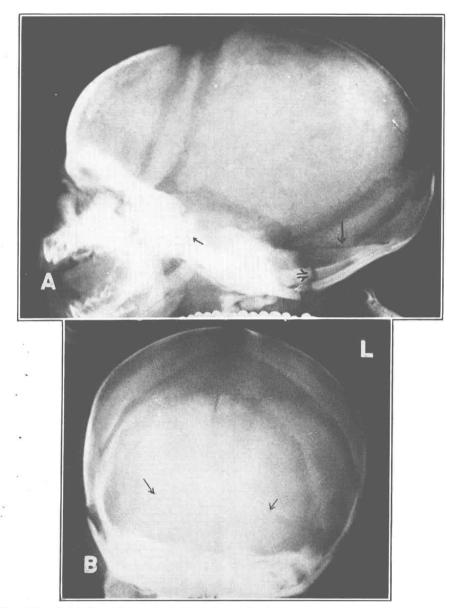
Lateral roentgenogram of newborn skull. The head is elongated. Note open anterior, posterior, sphenoidal and mastoid fontanelles, wide sutures, absence of aeration of frontal, sphenoidal and mastoid cells. There are no vascular or convolutional markings. The walls of the sella turcica are dense. The anterior clinoids are bulbous and longer than the posterior ones. Note the open spheno-occipital suture (short arrow). The anterior fossa slopes, is short and its floor is rather steeply convex upwards. The face is proportionately small compared with the skull. The mendosal (false) suture is present (long arrow). The synchondrosis between the supraoccipital and lateral-occipital region is clearly visible (double arrow).
